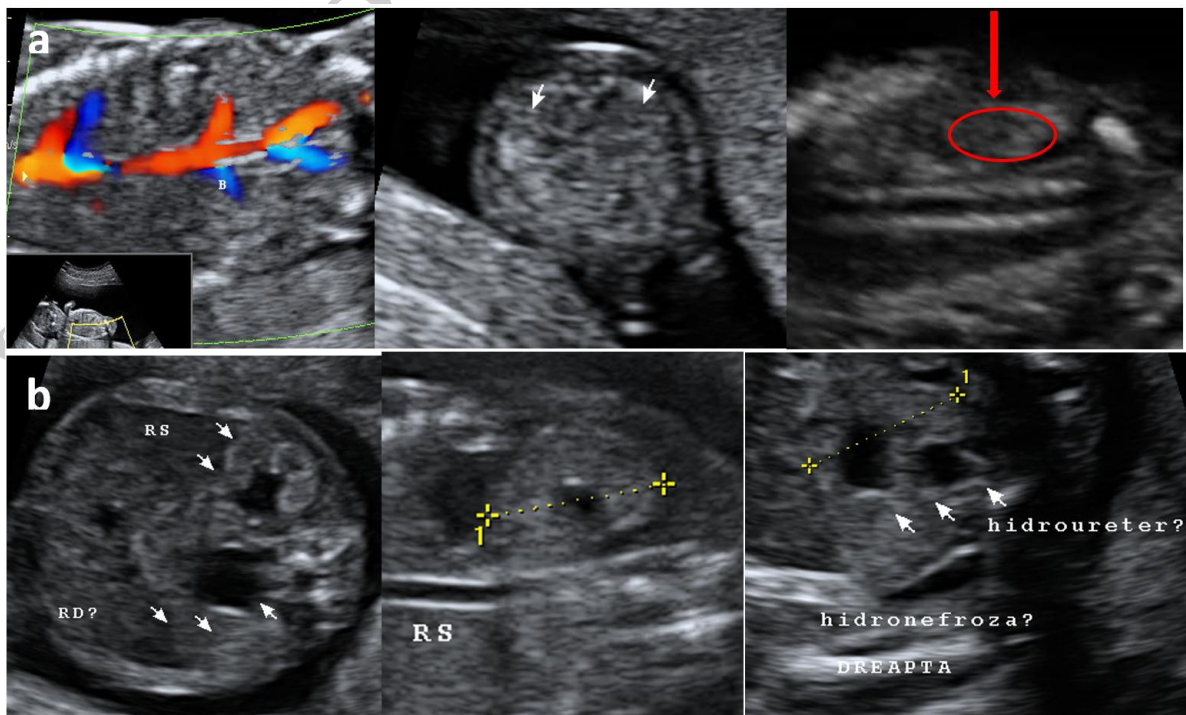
Case 2, ultrasound features 12+2 gestational weeks (a) and 18+1 gestational weeks (b).
